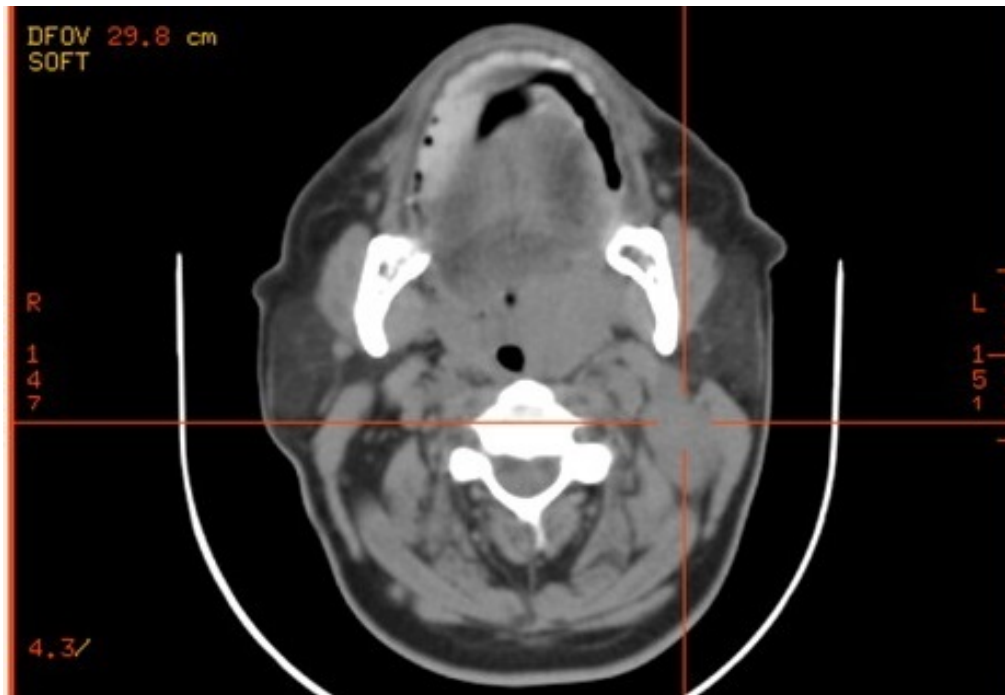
Axial dimension of a CT scanning image of head and neck cancer. The centerline shows the location of the primary tumor tissue. This images is modified from, [33]
